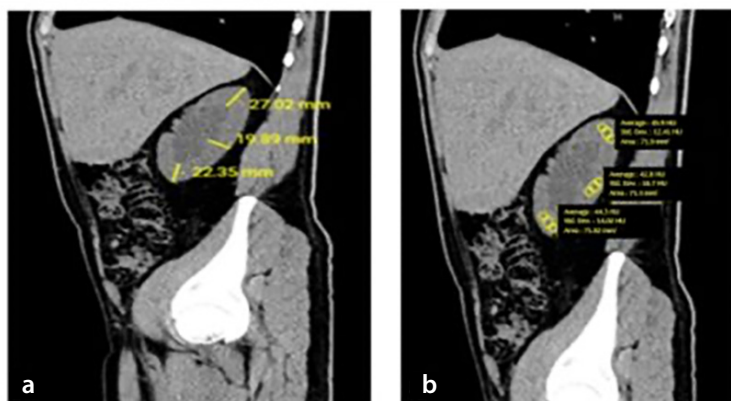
Sagittal non-contrast CT scan: (a) parenchymal thickness (mm) and (b) parenchymal density (HU) were measured using the freehand ROI option at the three thickest and most homogeneous levels without space-occupying lesions at the upper, middle, and lower poles of the kidney. The mean values of these measurements were calculated. CT, computed tomography; HU, Hounsfield units.
